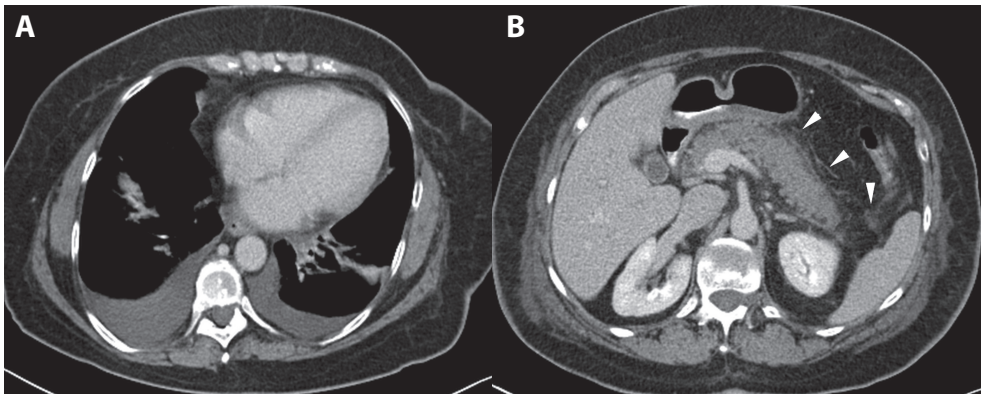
A 65-year-old woman with acute interstitial pancreatitis (MCTSI 4). (a) Contrast-enhanced CT of the lung bases shows bilateral pleural effusion. (b) CT at the level of the pancreas shows a normal enhancing pancreatic parenchyma with little peripancreatic fat stranding (arrowheads). The CT severity index is 2 (predicted mild pancreatitis), while the modified CT severity index credits two extra points for pleural effusion (MCTSI 4, representing predicted moderate severe pancreatitis).
